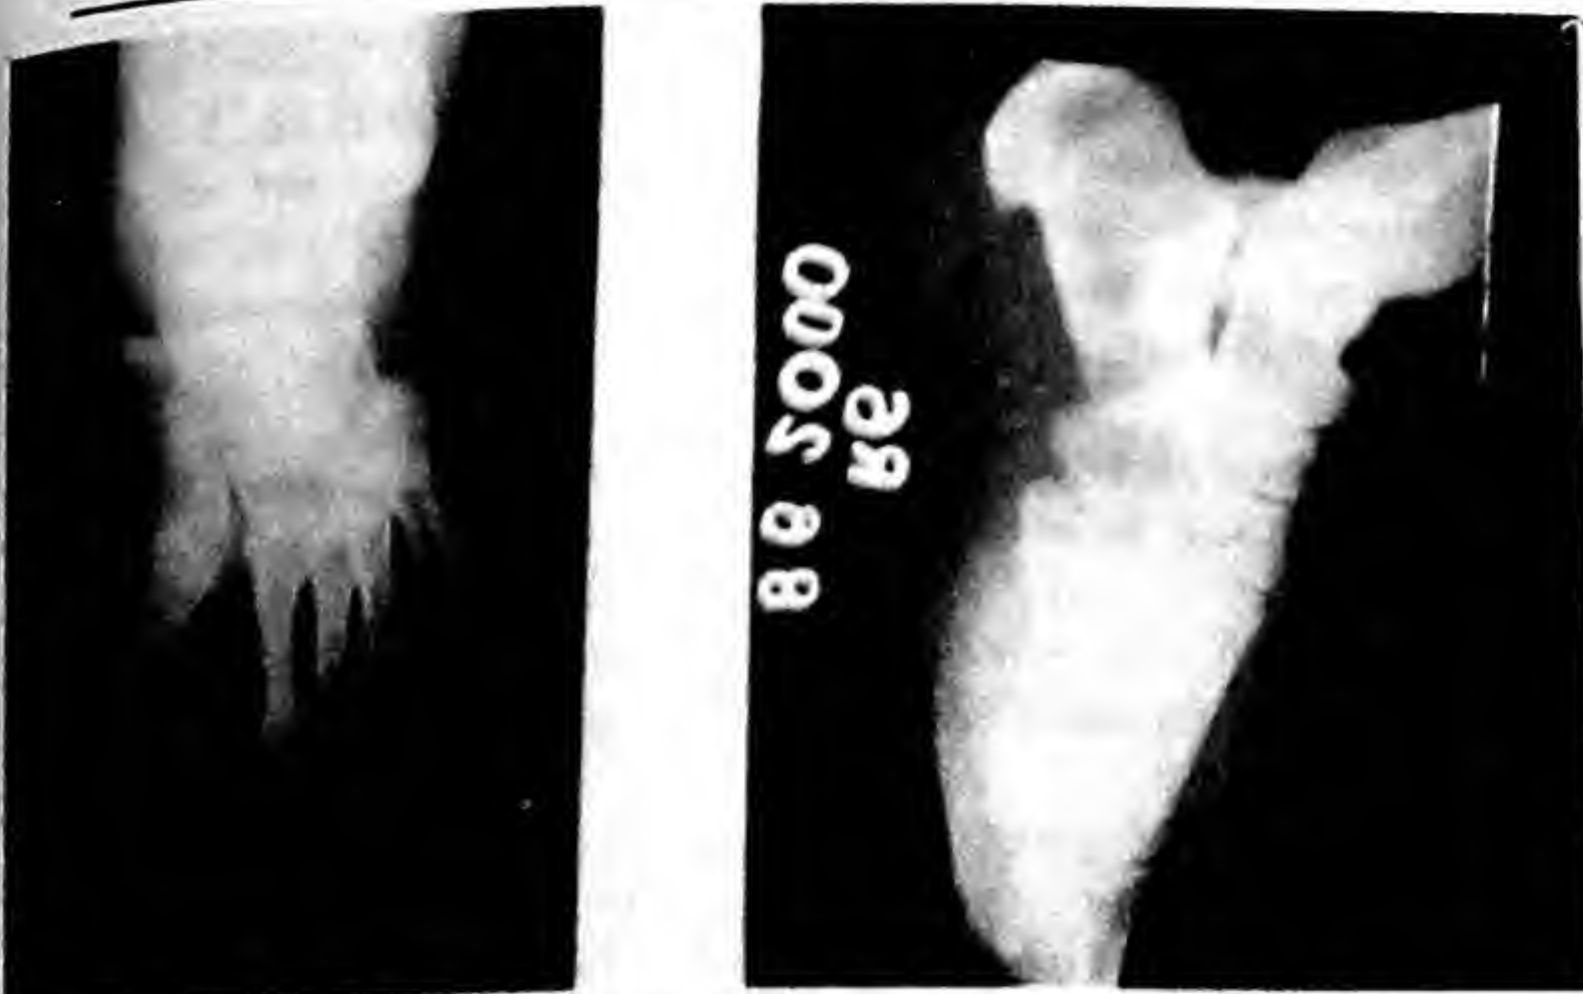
X-ray right foot demonstrating a soft tissue swelling between 1<sup>st</sup> and 2<sup>nd</sup> metatarsals with sclerosis and bowing of 2<sup>nd</sup> metatarsal.
